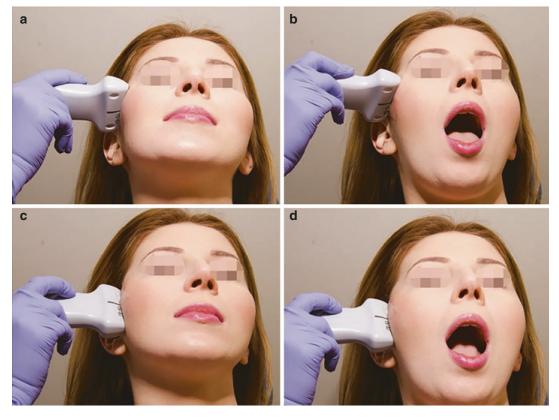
Ultrasound examination of the right TMJ. The transducer is placed parallel to the Frankfurt horizontal plane in closed (a) and open (b) mouth position as well as
